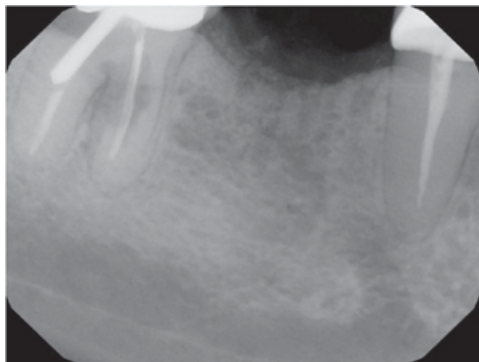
Post operative digital radiograph of the grafted site.
